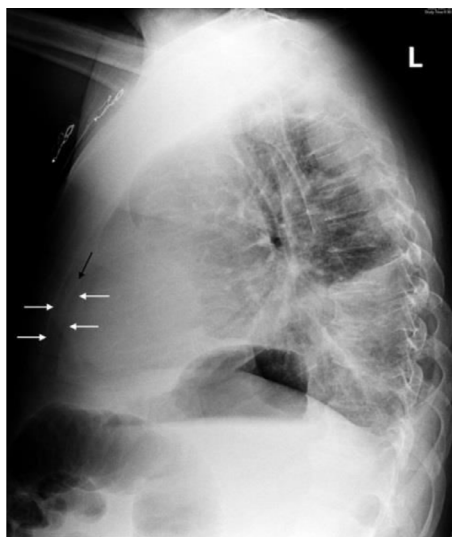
Lateral chest radiograph demonstrating a pericardial effusion by visualization of the “pericardial stripe” (radiopaque region (black arrow), which is the fluid density between the radiolucent epicardial and pericardial fat stripes (white arrows). Reproduced with permission from Li et al.<sup>69</sup>
